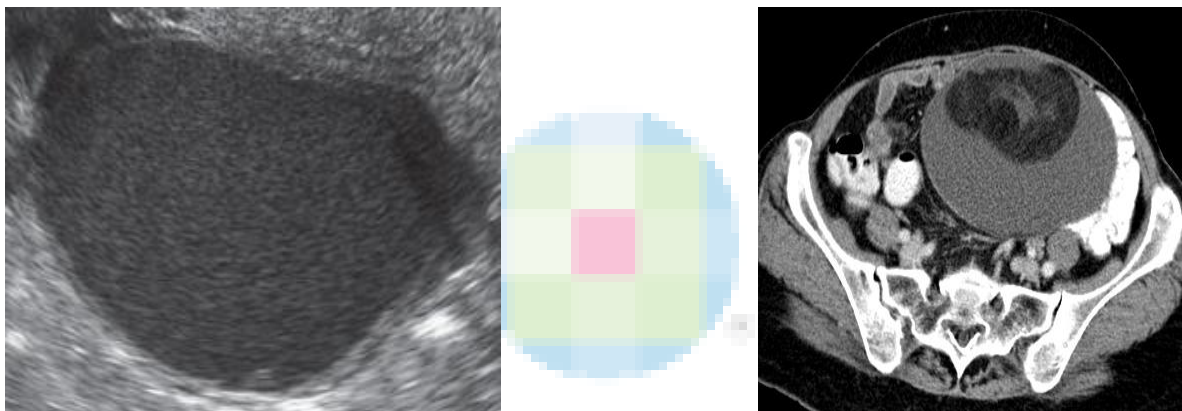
Sonography image of endometrioma showing cyst with homogeneous low level internal echoes in 29-year-old woman.
